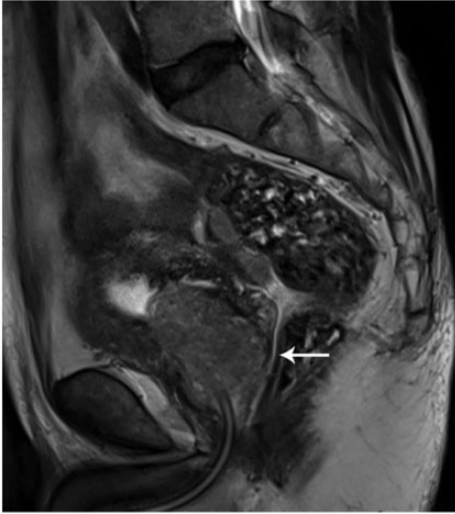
Magnetic resonance imaging of the prostate of a 71-year-old male patient that presented with recurrent oedema of the left lower extremity for 6 years showed that the prostate was significantly enlarged and partially protruded into the bladder (white arrow).
